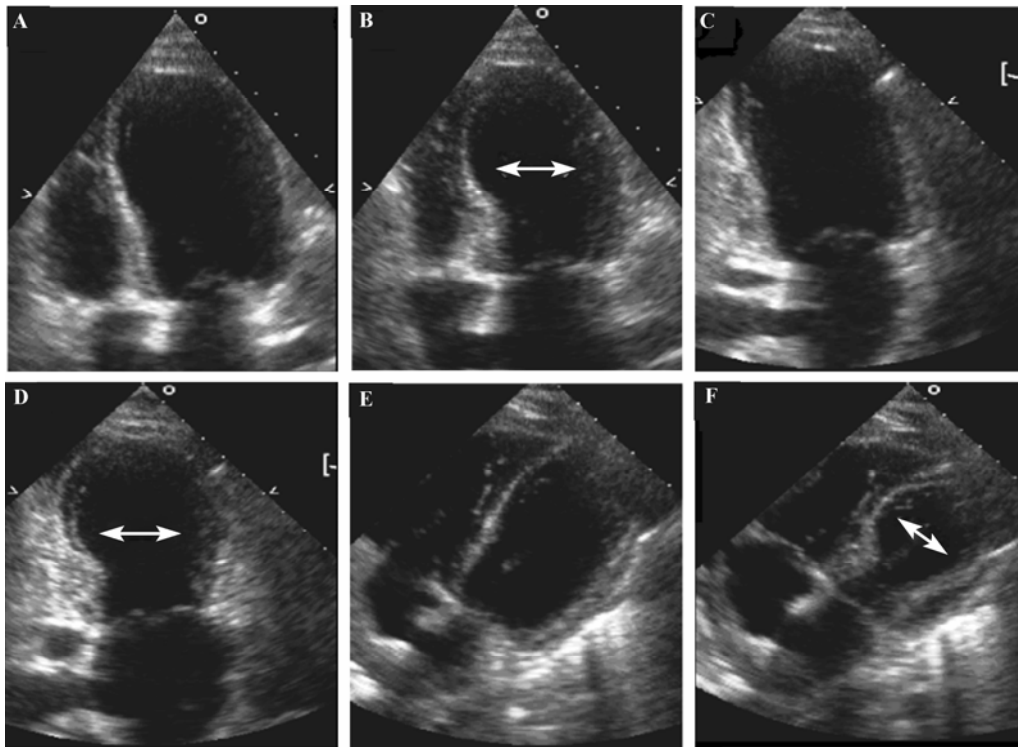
Case 2, echo still frames. (A): Apical 4 chamber view, diastole; (B): Apical 4 chamber view, systole; (C): Apical 2 chamber view, diastole; (D): Apical 2 chamber view, systole; (E): Subcostal 4 chamber view, diastole; (F): Subcostal 4 chamber view, systole. Arrows indicate akinetic areas.
